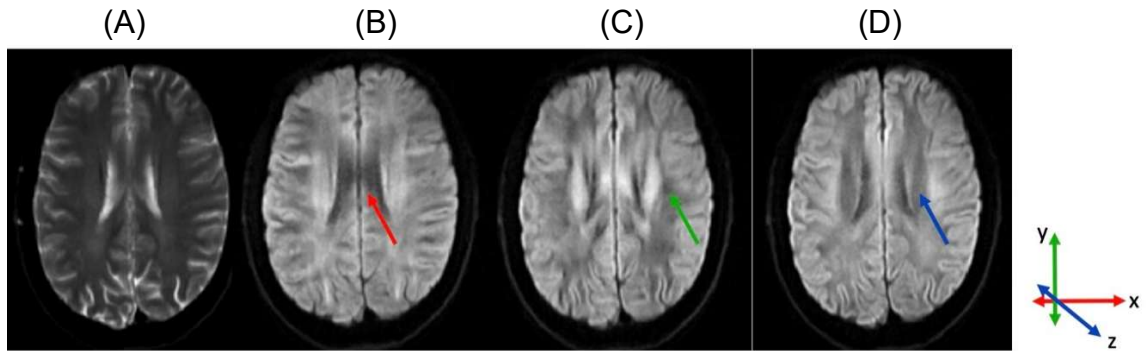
Diffusion-weighted images (DWI) from a healthy volunteer (male, 23 years) using $b = 1000 \text{ s/mm}^2$. (A) Non-diffusion-weighted image (b -value = 0). (B) Diffusion weighting encoded in the x -direction (please note that the corpus callosum shows a low signal, indicating high diffusion along the fibers, in red). (C) Diffusion weighting encoded in the y -direction (please note low signal in longitudinal fasciculus superior, in green). (D) Diffusion weighting encoded in the z -direction (please note low signal in the corona radiata, indicating high diffusion along the fibers, blue arrow). The x -axis corresponds to a left–right direction, the y -axis is anterior-posterior, and the z -axis is head to feet. Low intensity in DWI in the ventricles in the three directions indicates free diffusion.
